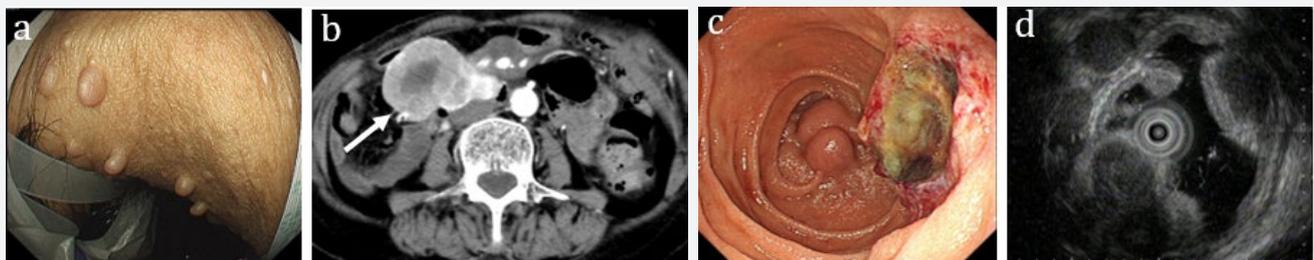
Diffuse cutaneous multiple neurofibromas on the skin (a). Abdominal computed tomography (CT) revealed tumors (arrow) with contrast effect in the second of the duodenum (b). Gastrointestinal endoscopy revealed several submucosal tumors with ulcer in the second of the duodenum (c). Endoscopic ultrasound revealed multiple low echoic masses from the muscle layer (d).
